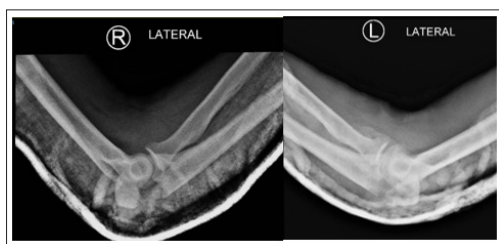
X-ray of Bilateral Elbow Showing Trans Olecranon Fracture, R: Right Elbow, L: Left elbow.
